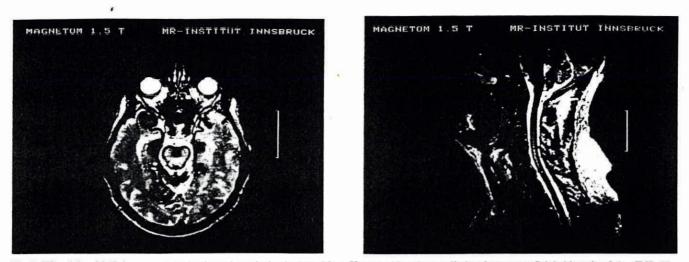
T2 weighted MR images of the brain and cervical spinal cord in a 58-year-old patient suffering from superficial siderosis of the CNS. The axial image (A) reveals a signal void of the temporal lobe surface, the brain stem and vermis cerebelli. The sagittal image (B) of the cervical spine confirms the abnormal T2 shortening over the vermis cerebelli, brain stem and cervical spinal cord.
